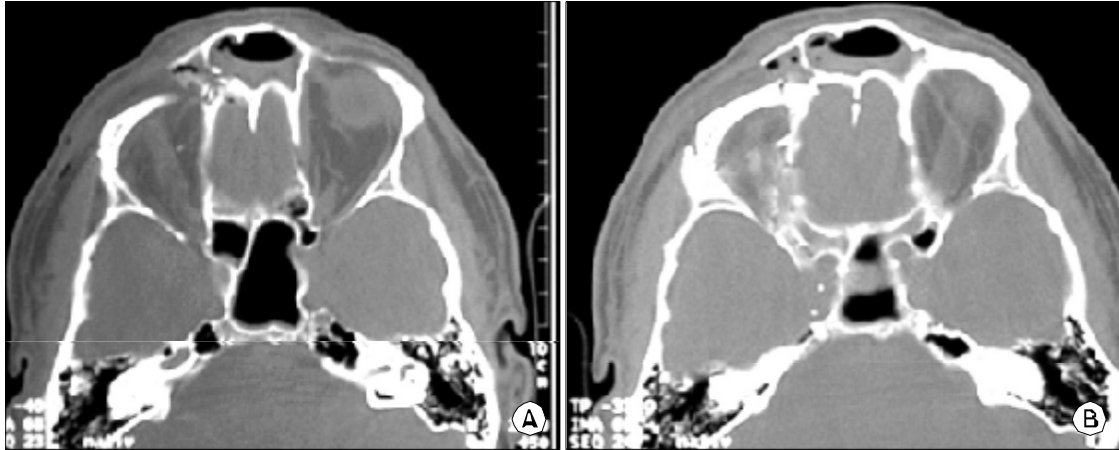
The CT view of multiple maxillofacial bone fractures.
